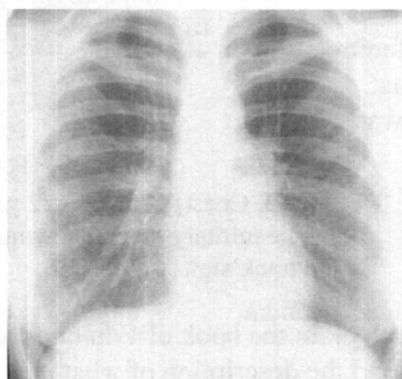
Chest X-ray of a 26 year old female sport diver (Case 4).
